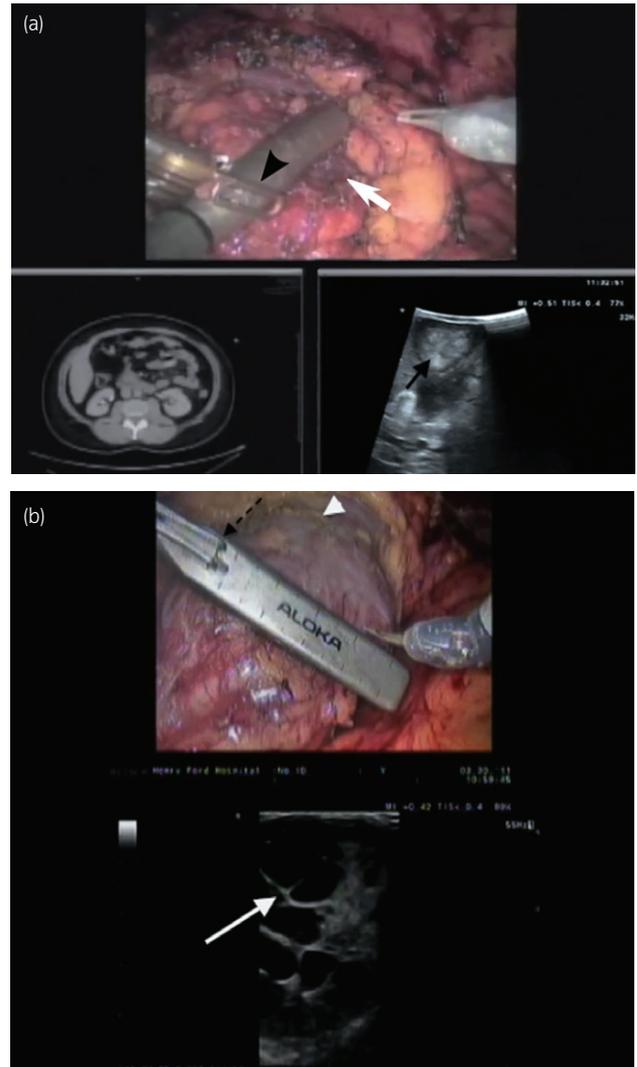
(a) Laparoscopic ultrasound probe being used for identification of a right renal mass (solid white arrow on upper console image; solid black arrow on lower TilePro ultrasound image). The surgeon is trying to grab the laparoscopic probe with the robotic instrument to adjust the position (black arrow-head). (b) Robotic ultrasound probe being used to identify a right renal cystic renal cell carcinoma (solid white arrow). The robotic instrument is engaged with the notch on the probe (dashed black arrow), allowing the surgeon to independently maneuver the probe to identify tumor margins. The arrowhead notes the scored resection margin of the far side of the tumor.
